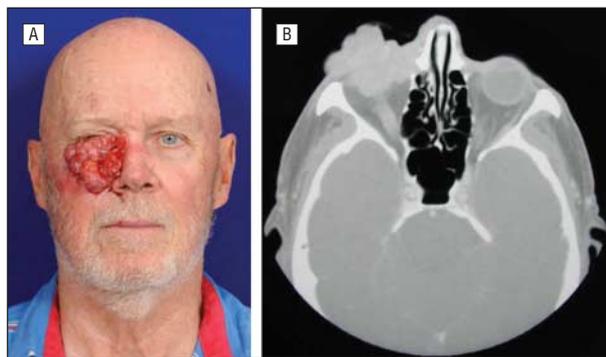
Basal cell carcinoma involving the right orbit, cheek, and nasal wall. A, A 72-year-old man with a 10-year history of a basal cell carcinoma involving the right orbit and extending to the cheek, inferiorly, and to the right nasal wall and ala, medially. B, Axial view of a computed tomogram showing invasion into the right orbit and nasal wall.
